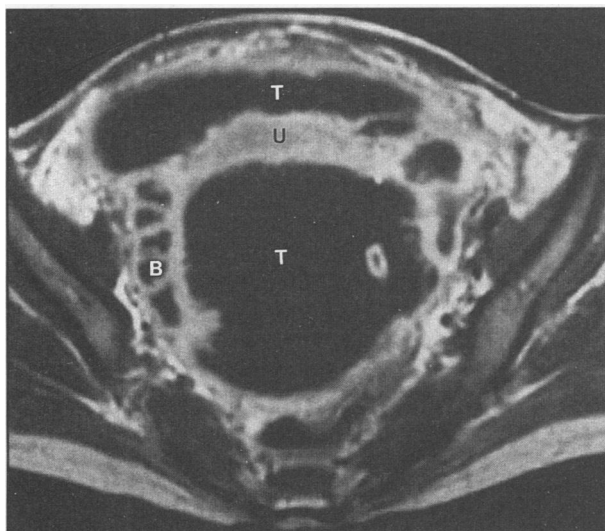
A transverse, gadolinium-enhanced, T1-weighted magnetic resonance imaging scan reveals numerous fingerlike interdigitations and enhancing nodular opacities extending inward from the abscess wall. Adhesions to adjacent small bowel (B) are also shown. T = tuberculosis abscess, U = uterus
